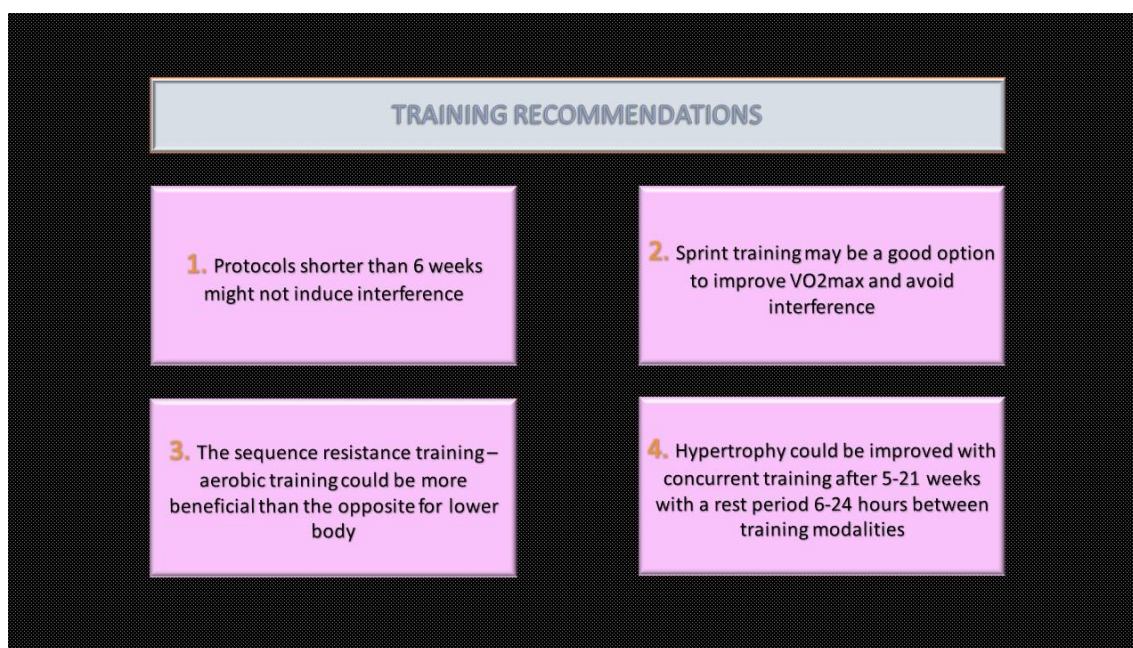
Optimizing the benefits of CT. Adapted by Berryman, Mujika & Bosquet I (2018)*
